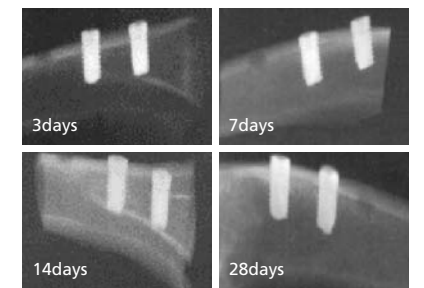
Radiographic features of 3rd, 7th, 14th, 28th day after implantation.
